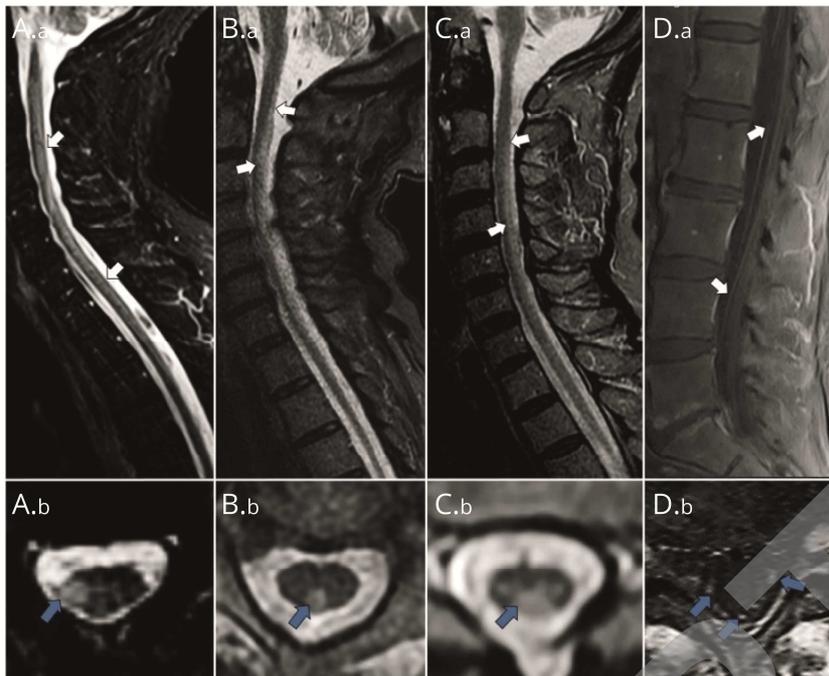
MRI spine abnormalities in paraneoplastic myeloneuropathies.
